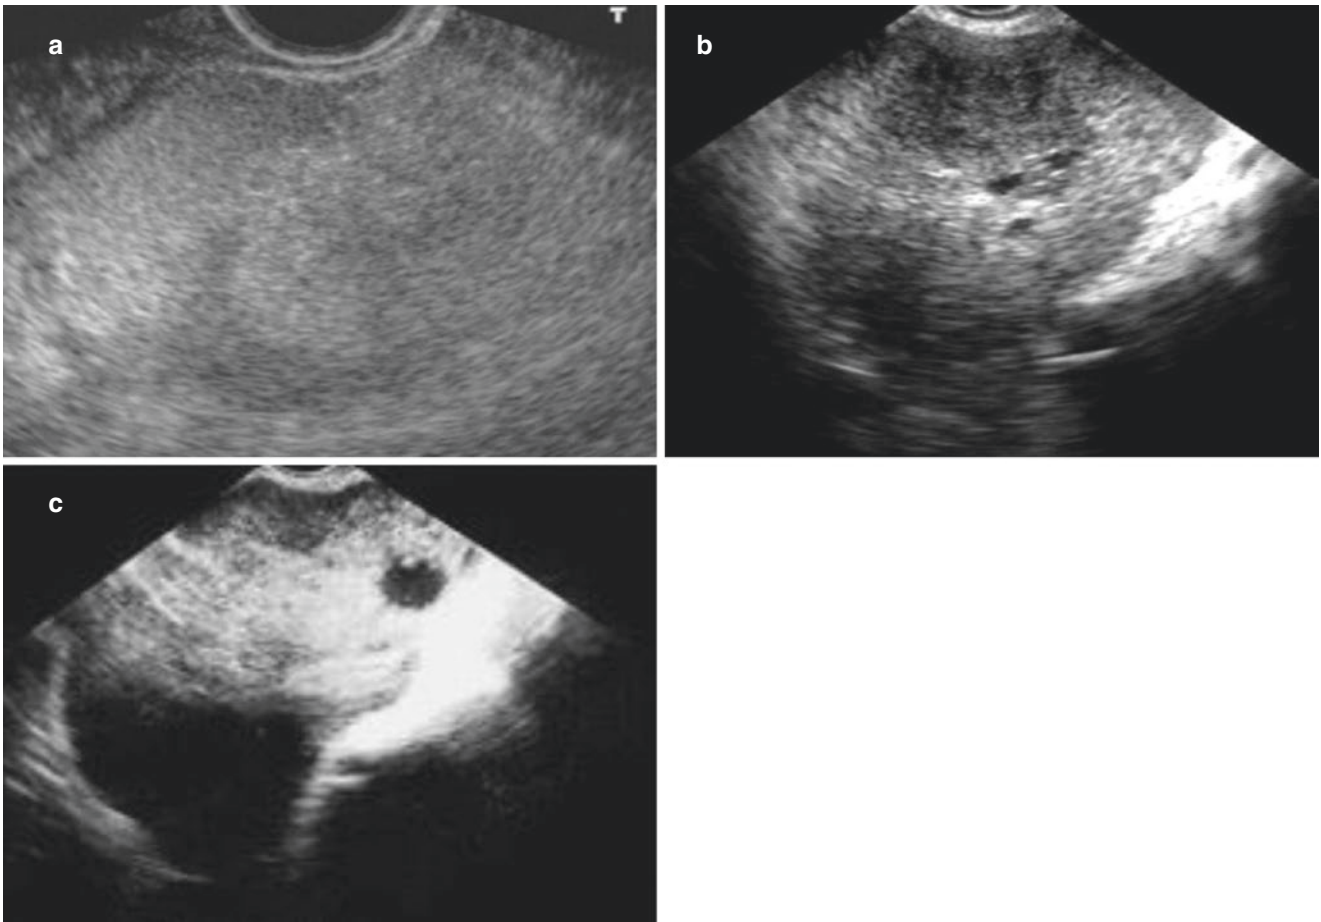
Ovarian solid tumor. (a) Sonogram shows a homogenic solid mass in the pelvic cavity, with similar echoic characteristics to uterine fibroma. Ovarian fibroma is confirmed by operation. (b, c) A 21-year-old patient represented with an abdominal mass. The ultrasonography
